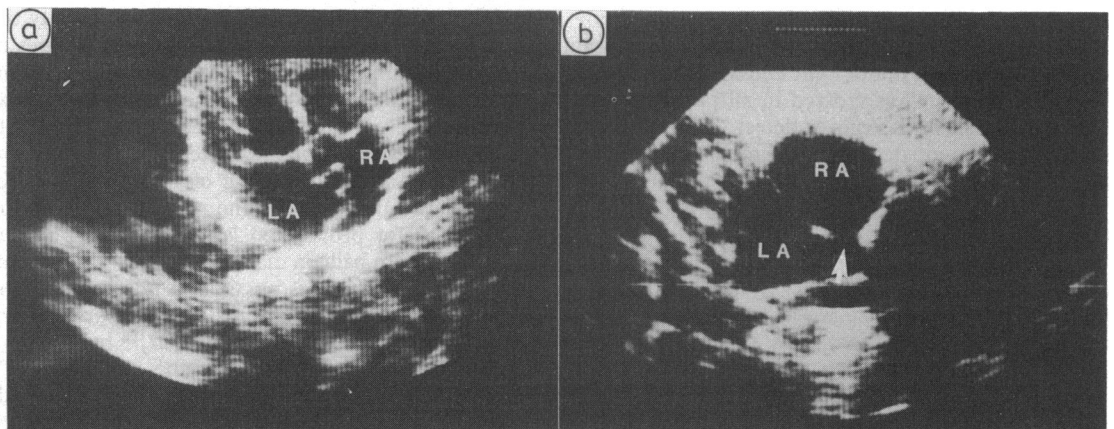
Echocardiograms showing (a) an aneurysm of the intra-atrial septum protruding into the right atrium. The aneurysm was associated with a large fenestrated septal defect, although no echo free areas are seen. (b) A sinus venosus defect produced an echo free area (arrow) in the upper atrial septum.
